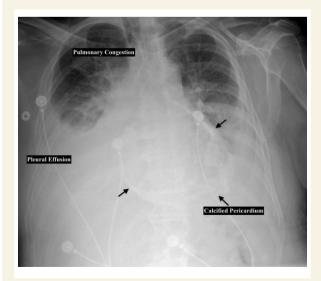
Chest radiography showing calcified pericardium, pulmonary congestion, and pleural effusions.
